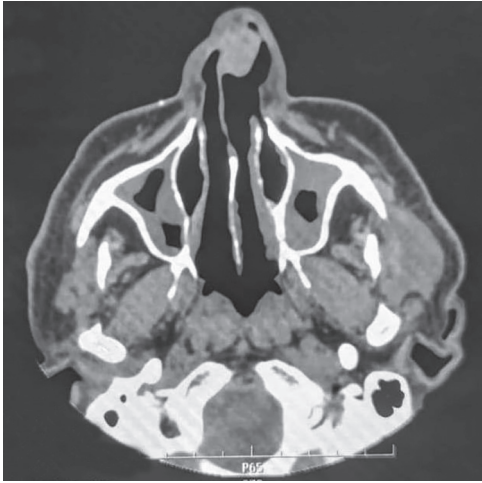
CT scan of nasal cavity and paranasal sinuses showing a homogenous soft tissue mass of size approximately 1.5 × 1 cm arising from the nasal septum
